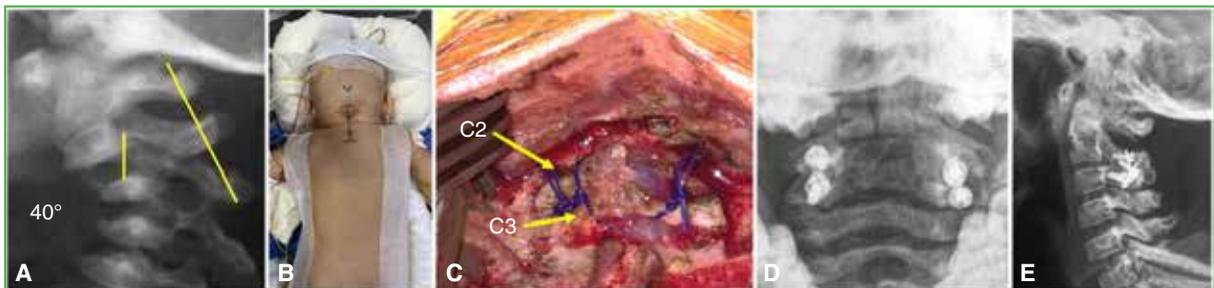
9-month-old girl with a history of a traffic accident, presenting with central spinal cord syndrome and right hemidiaphragm paralysis. A. Lateral radiograph of the cervical spine showing unilateral C2-C3 dislocation with 40° kyphosis. B. Prone operative positioning and skin marking. C. Intraoperative image after reduction and double sublaminar cerclage of C2-C3 using Prolene® 2.0 suture (blue). D and E. Cervical spine radiographs, transoral anteroposterior and lateral views, obtained at 9 years of follow-up. Facet osteosynthesis using 2.0 mm diameter minifragment screws and a custom titanium miniplate.
